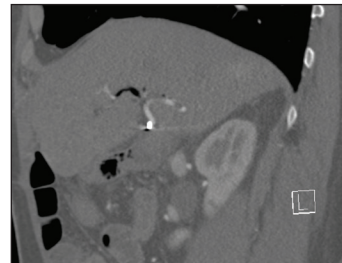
Oblique-sagittal reformatted CT shortly before the patient was discharged from the hospital showing the coil in the completely filled aneurysm next to the patent hepatic artery.
